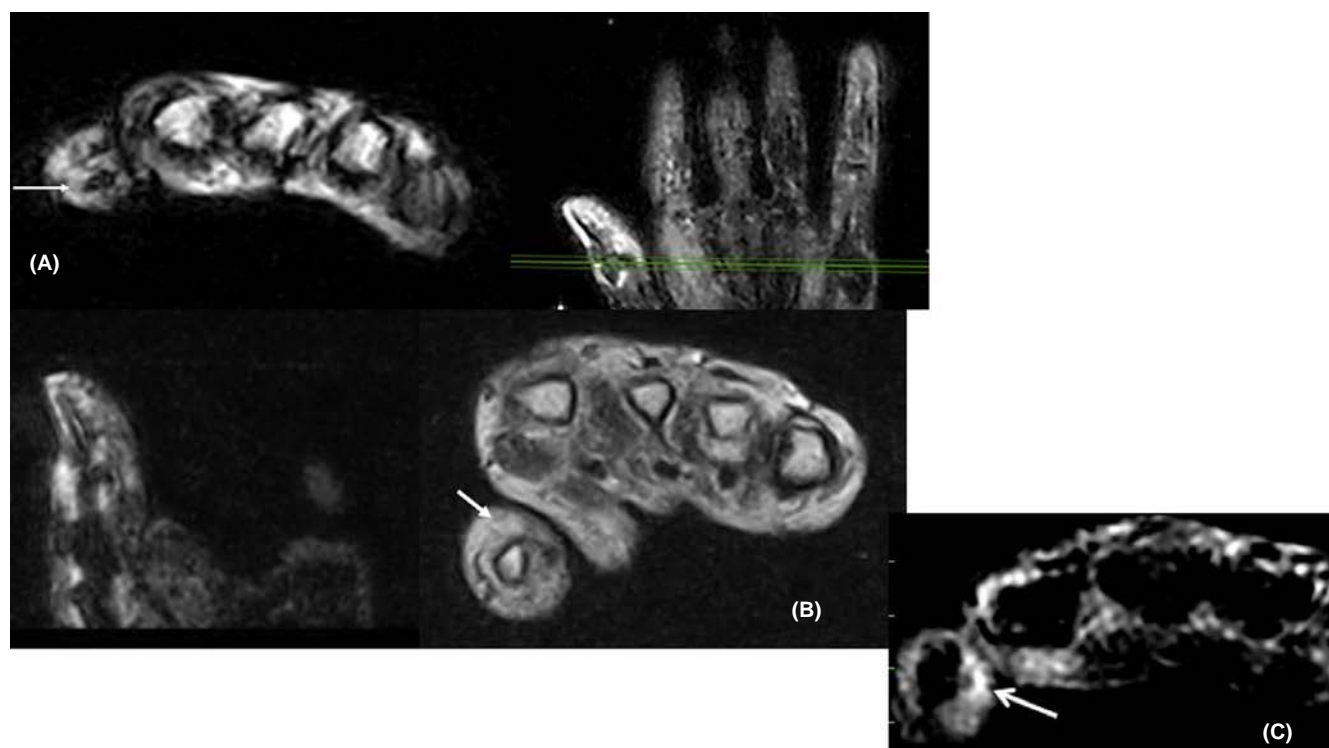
A,B, Extremity magnetic resonance imaging (MRI) of hand in STIR coronal and axial sequences, with arrows pointing to synovitis at the interphalangeal (IP) joint of the thumb. C, Extremity MRI of hand in STIR axial sequence with arrow pointing to tenosynovitis at the IP joint of thumb
